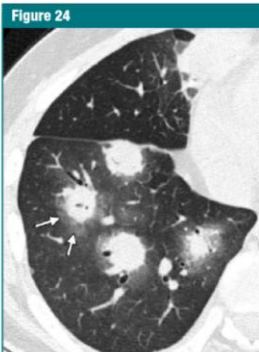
Transverse CT scan shows several nodules exhibiting the halo sign (arrows).
